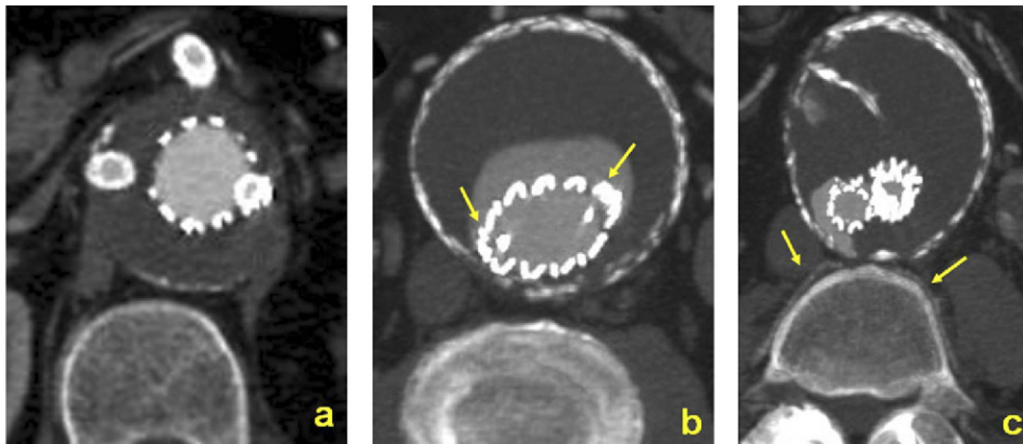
Computed tomographic angiography (CTA) 3 days after repair of the aneurysm. a, Paravisceral stent graft with stents placed in both renal arteries and the superior mesenteric artery (SMA) without endoleak. b, Flow into the aneurysm at the level of the paraplegia prevention branches (PPBs; yellow arrows). c, Perfusion of one pair of distal lumbar arteries from the aneurysmal sac (yellow arrows).
